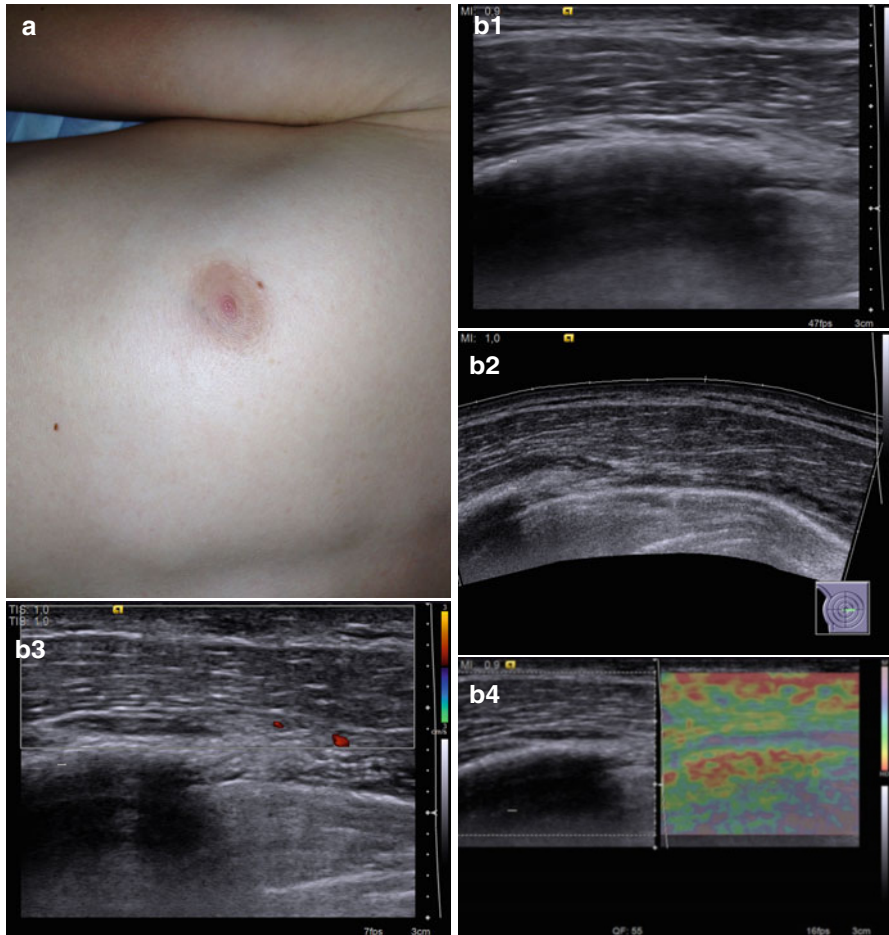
Healthy breast, 14-year-old boy. (a) Photo (b) (1–4) Grayscale US, CDI, and ultrasound elastography
